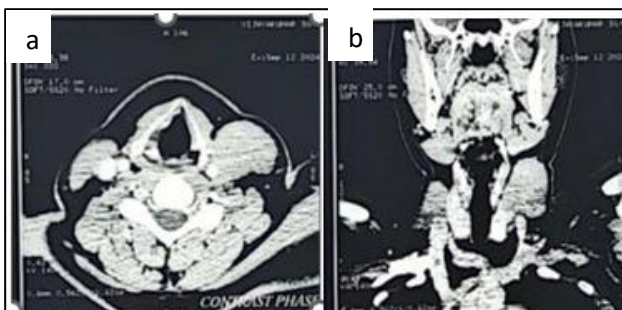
Contrast enhanced CT scan (a) axial cut showing well defined homogeneous minimally enhancing isodense lesion measuring 3.6×2.1×2.5 cm in the upper cervical region. (b) coronal cut showing swelling compressing left IJV.
